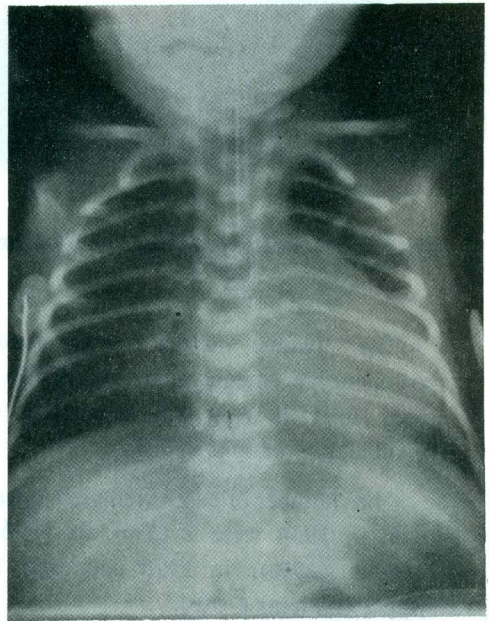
Preoperative chest x-ray shows cardiomegaly and pulmonary congestion (patient is intubated).
